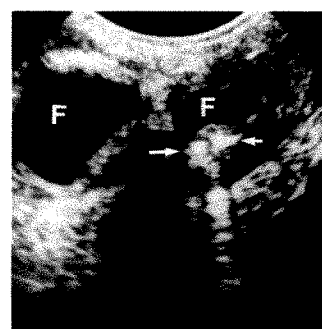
Congenital inguinal hernia. Transverse sonogram shows fluid (F) and hyperechoic foci (arrows) in scrotum of an infant. Plain film showed scrotal calcification associated with meconium peritonitis, which had extended through processus vaginalis. (Courtesy of Henrietta Rosenberg, Philadelphia).
